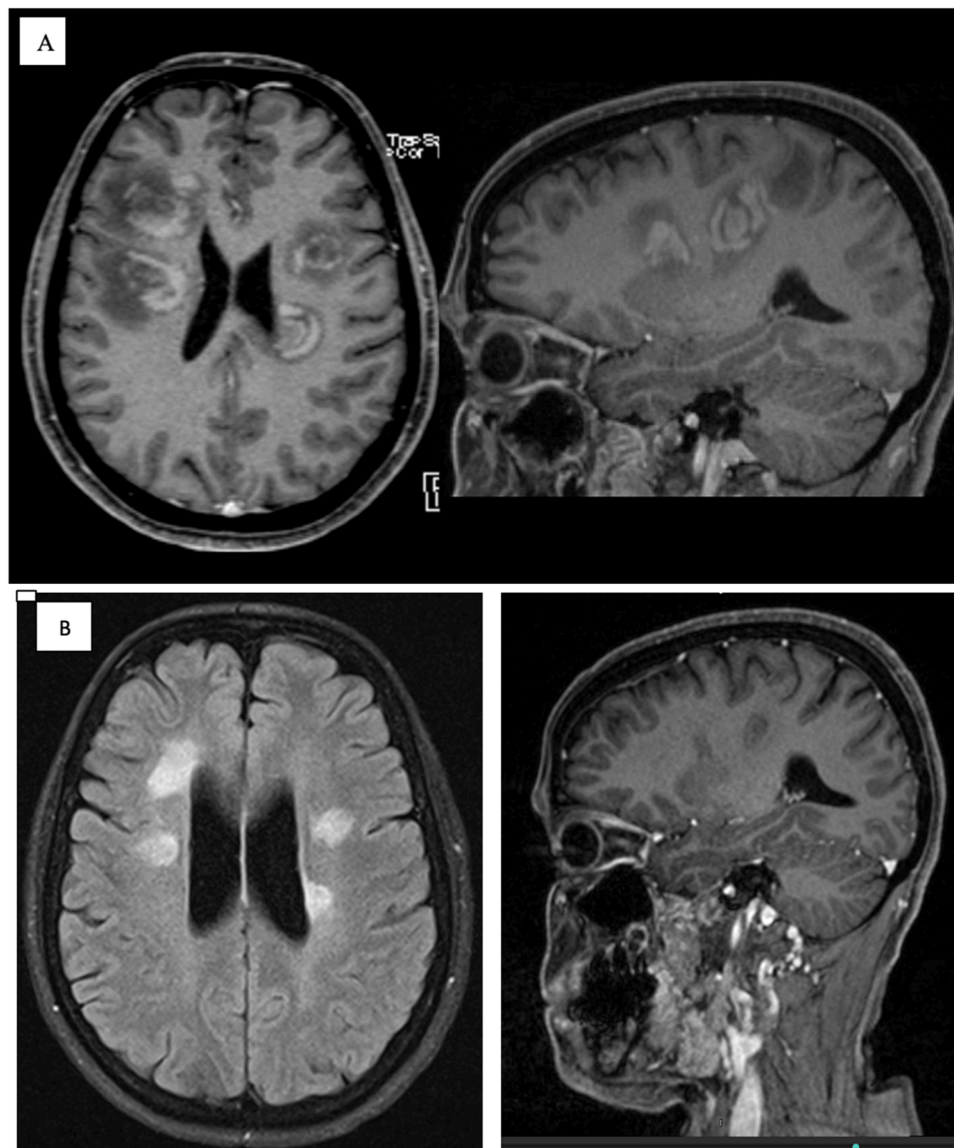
1A MRI at admission (January 2019): At admission (January 2019), Multifocal subcortical and periventricular lesions with irregular, ring like enhancement. 1B Follow up study (December 2022), Stable MR appearance of the previously described BCS lesions, no more signs of disease activity or newly developed lesions seen.
